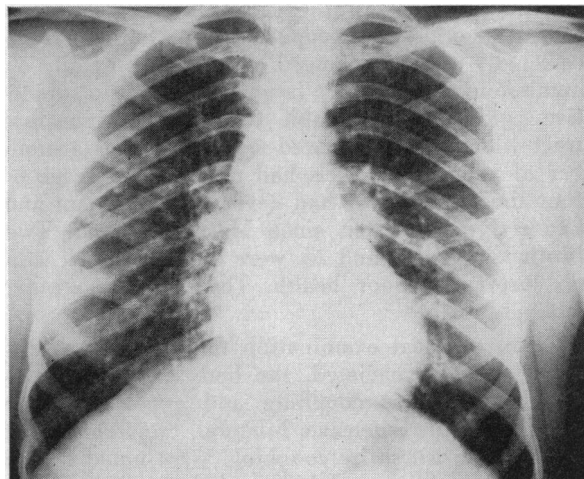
X-ray film of chest taken April 13, 1955, showing the extensive roentgenographic changes since 1950. Patient 21 years of age at this time. This film is identical with one taken May 17, 1954. Note the prominent hilar shadows and the mottled "snowflake" infiltrates resembling tuberculosis. The result of a tuberculin test was negative.
